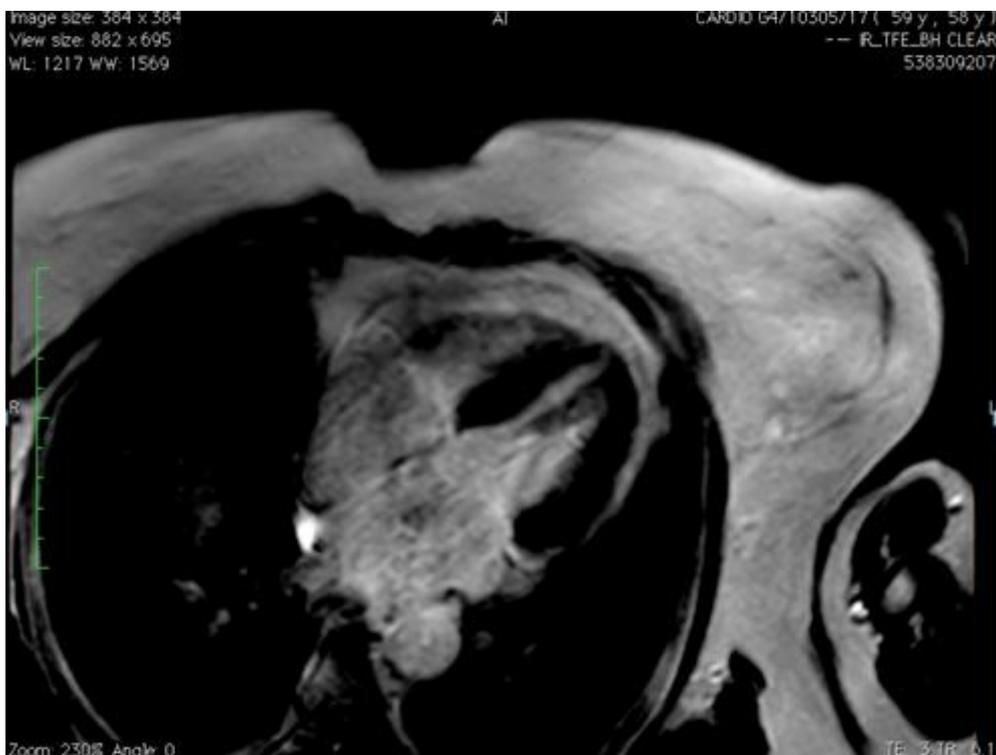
MRI section 4 cavities in late enhancement sequence 10 minutes after gadolinium injection showing no contrast enhancement
